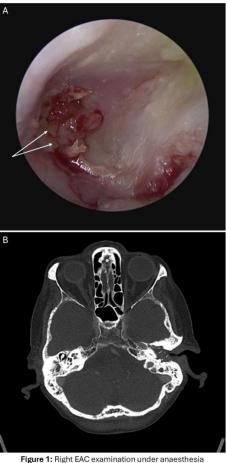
Right EAC examination under anaesthesia demonstrating exposed bone (white arrows) consistent with EAC osteonecrosis (A). Axial section of CT petrous temporal bones showing erosion of the floors of the EACs mainly anteriorly and inferiorly, with changes more marked on the left side supportive of bilateral EAC osteonecrosis (B).
